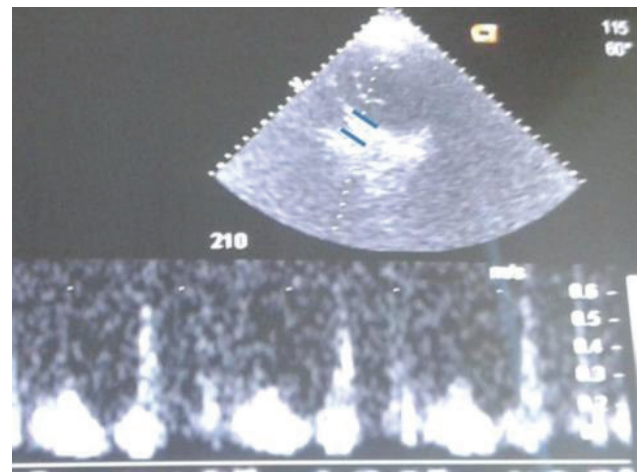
CS in B mode with Doppler flow traces below.
